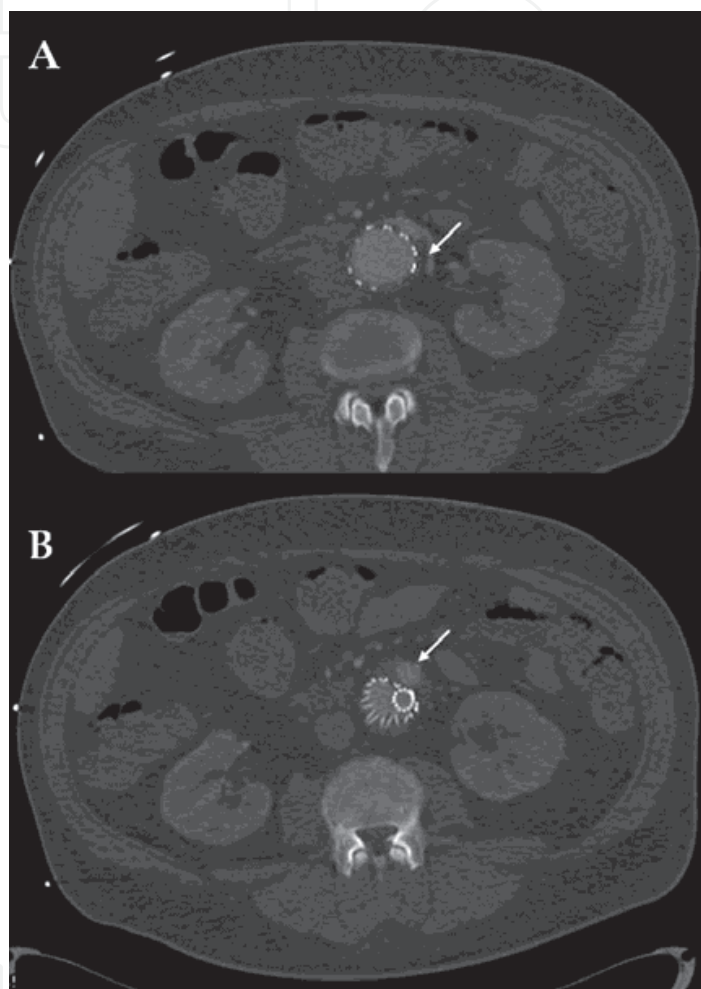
Follow-up CT-angiography detecting an early type 2 endoleak (B, *arrows*) because of the inverted flow into the inferior mesenteric artery (A)
